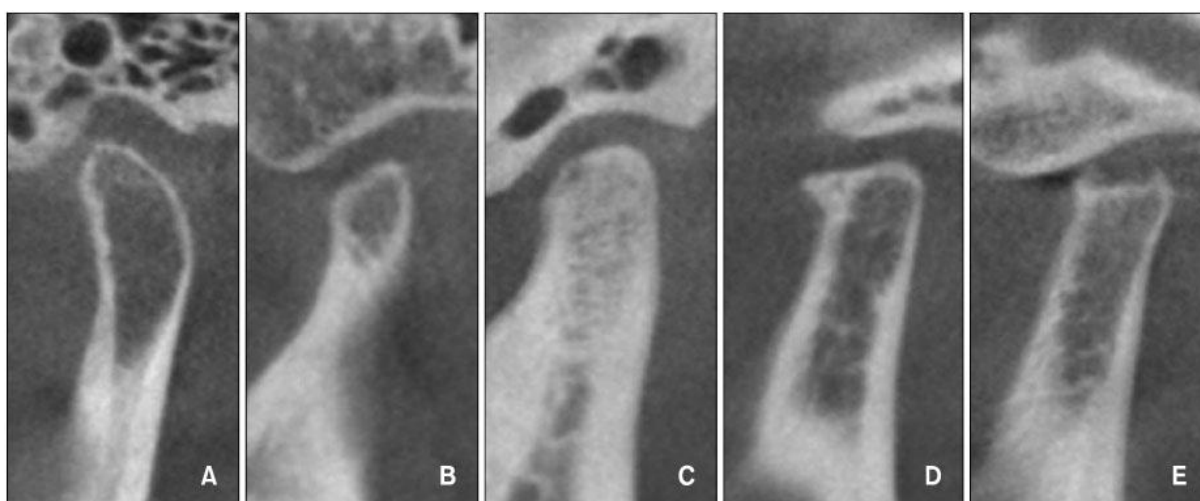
Different types of condylar shapes in cone beam computer tomography sagittal imaging (A - normal; B - flattening; C – sclerosis; D – osteophyte; E – erosion) (Lee *et al.*, 2010).
